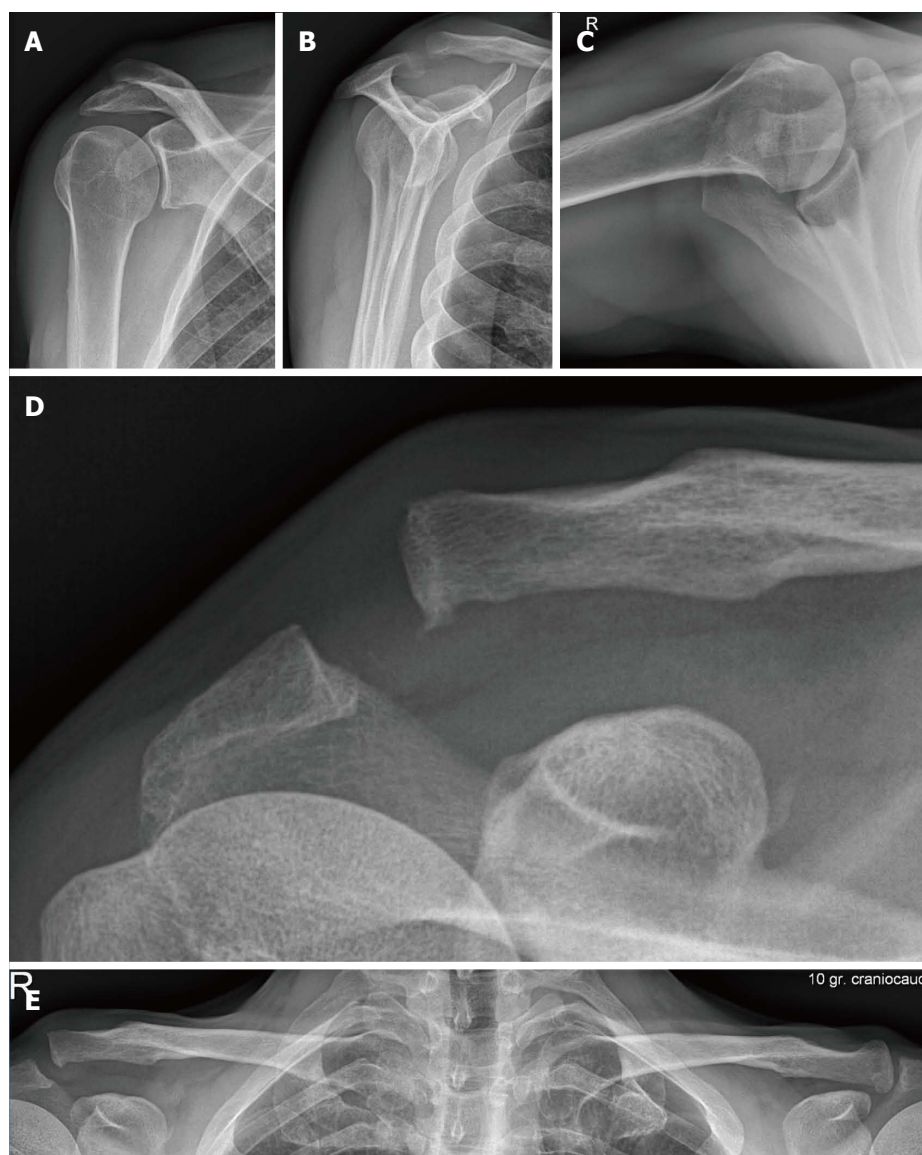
Standard radiographic series of the shoulder. A: A true anterior-posterior view; B: Scapular Y lateral view; C: Axillary view; D: Zanca view; E: In case of acromioclavicular separation, a bilateral Zanca view can be useful.
